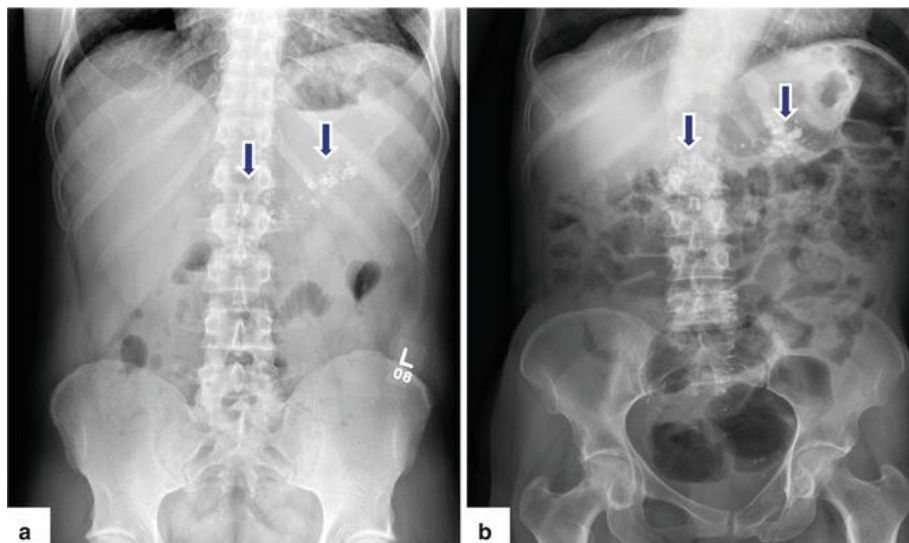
Chronic pancreatitis on plain abdominal radiographs: Abdominal radiographs (a, b) of two alcoholic patients show multiple coarse calcifications in the topography of the pancreas (arrows) [29]
